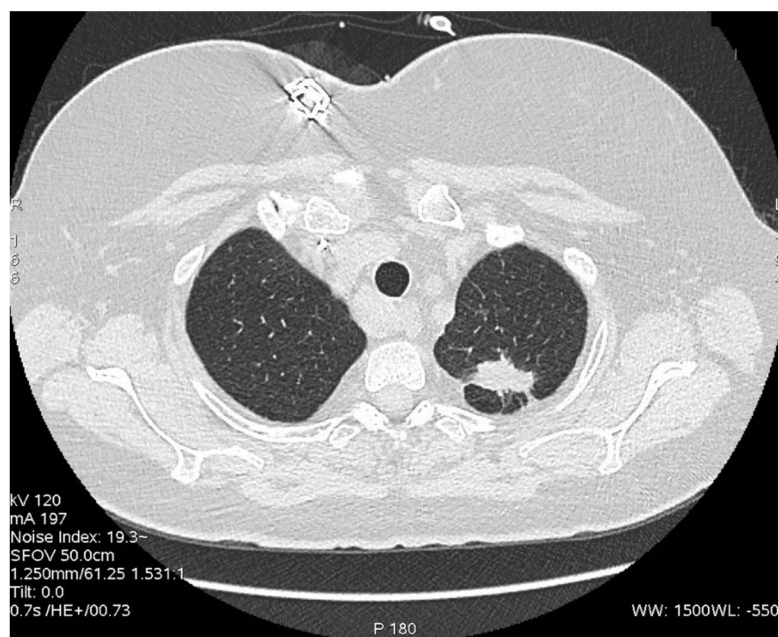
June 2020. High-resolution computed tomography of the chest showing the presence of a spicular tumor in the upper lobe of the left lung
